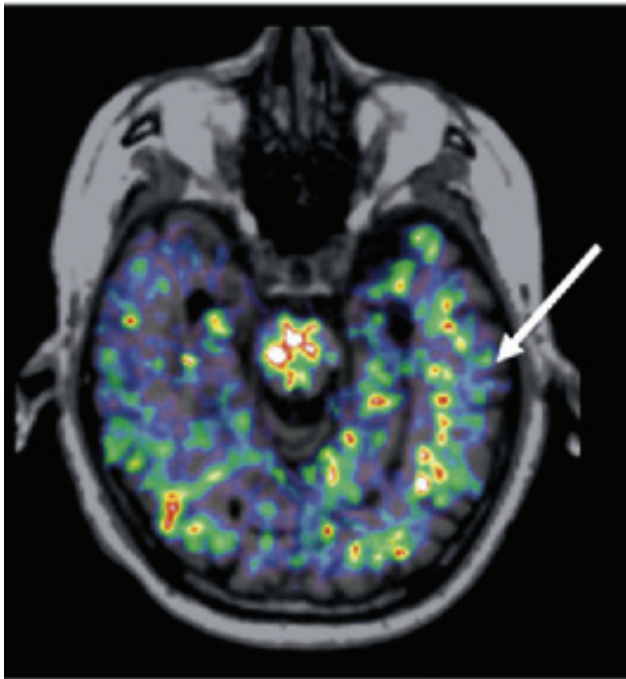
FIGURE E-2 Positron tomography image showing sites of inflammation using the tracer ^{11}C -PK11195 with superposition of the positron emission tomography emission on a magnetic resonance imaging anatomical image. SOURCE: Cagnin et al. (2007), with kind permission from Springer Science & Business Media.
